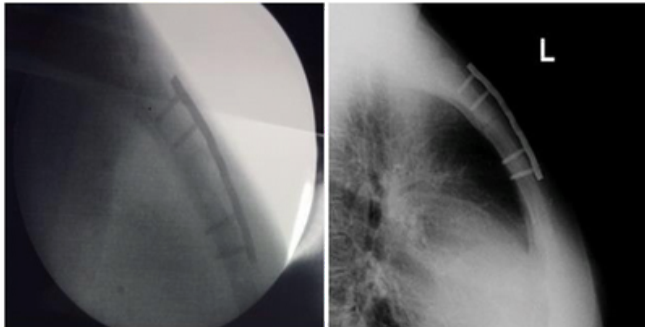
(Left) Post-operative C-arm lateral view of sternal plate. (Right) Lateral view chest x-ray showing sternal plate in place and alignment of fracture.
